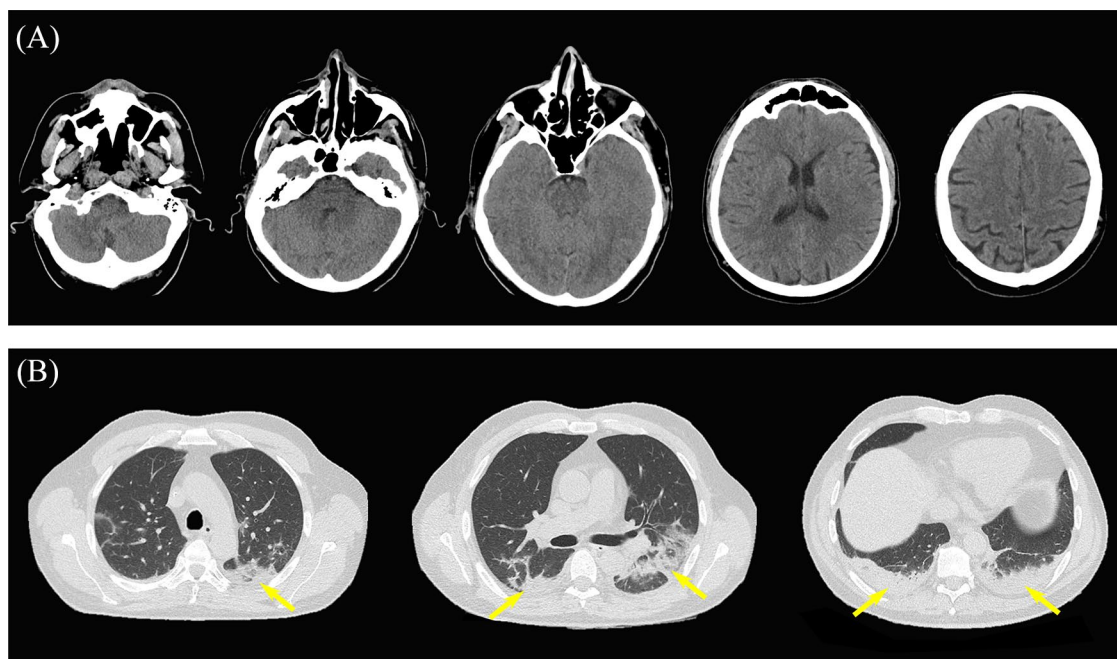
Brain and chest CT. Axial brain non-contrast CT images with an unremarkable appearance (A). Plain axial chest CT images showing multiple, bilateral, and peripherally distributed opacities (arrows) with a ground glass pattern (B). CT, computed tomography.
